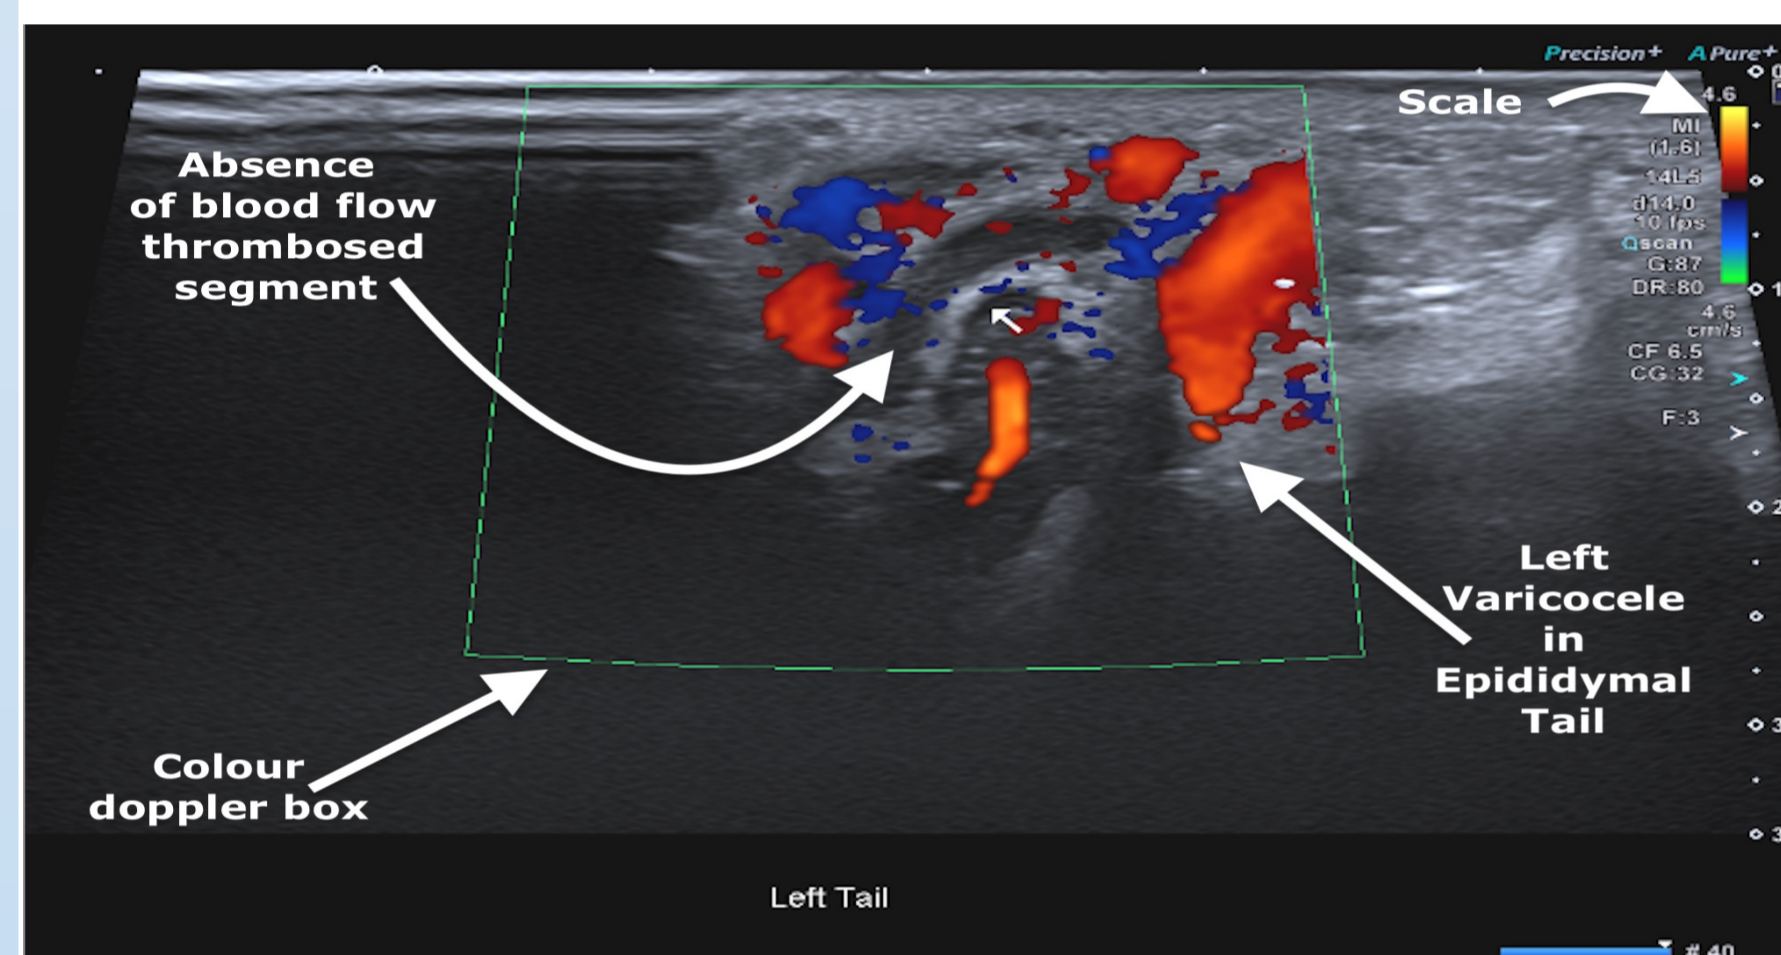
Colour doppler imaging of the left epididymal tail with a linear hypoechoic structure, appearing avascular during Valsalva (Hospital X, 2023).
